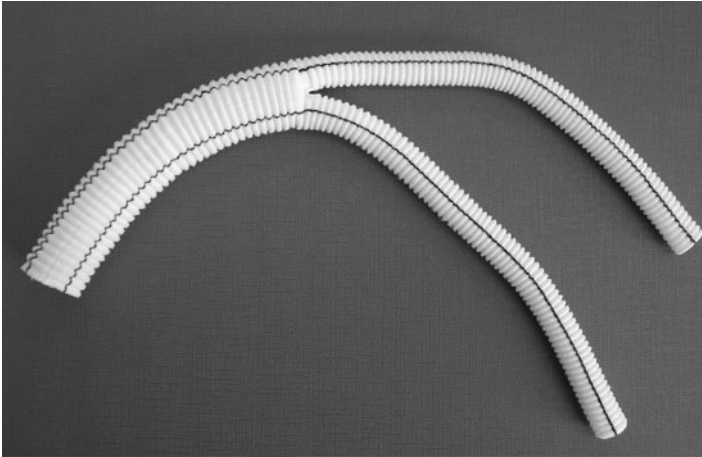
A photograph of a bifurcating Dacron vascular graft. The structure is corrugated to allow for expansion when placed in vivo. The black line is for X-ray identification
